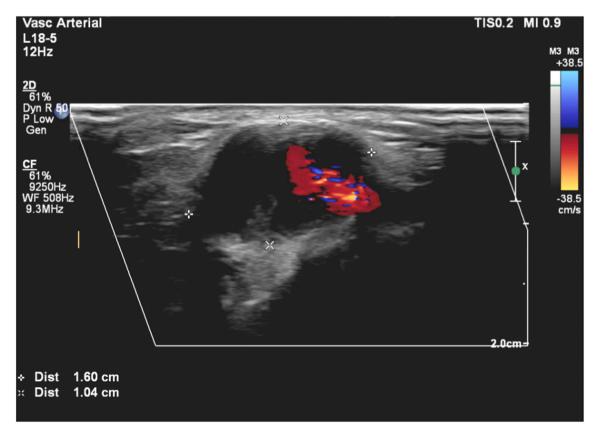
Ultrasound scan of snuff box radial artery aneurysm.
